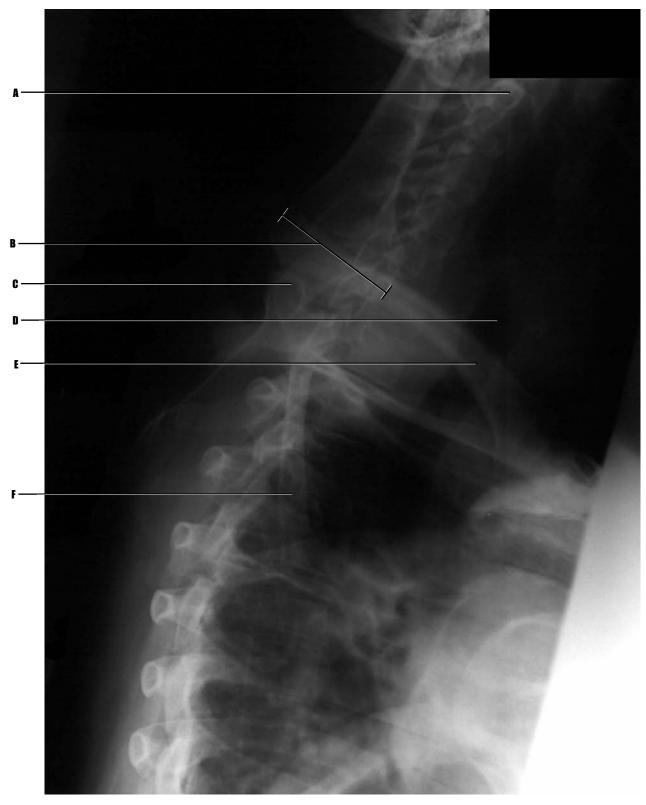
Adult patient, plain film radiograph, "swimmer's view" of cervical and upper thoracic spine. A "swimmer's view" is a radiographic projection used to more adequately visualize C7-T2 vertebrae.
